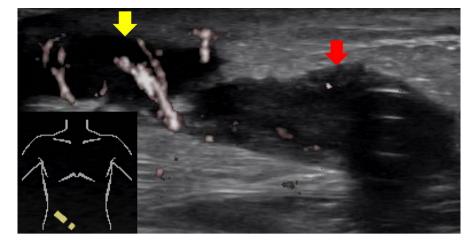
Ultrasound image shows the peritoneal dialysis catheter and hypoechoic zone around the catheter (indicated by the red arrow). Spread of the peri-catheter collection toward the abscess. The abscess exists just under the skin (indicated by the yellow arrow). The intense power Doppler signal indicates abundant blood flow
